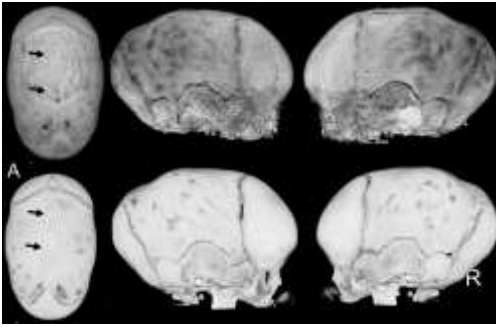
Skull images of patient 5 with sagittal synostosis. Top row, 3D-rendered BB-MRIs at the age of 4 months. Bottom row, 3D-rendered CT images at the age of 5 months. The arrows point to the location of the fused suture.
